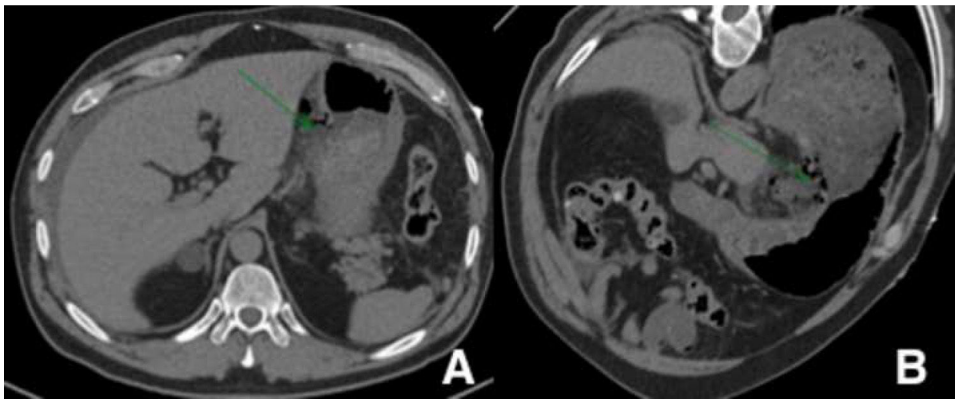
Computed tomography. The green arrow shows the rupture of the stomach with free air. A) Axial view, B) Oblique view.
